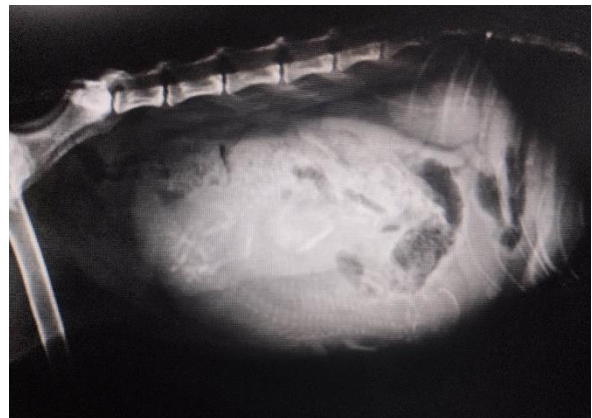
X-ray reveals presence of fetus
